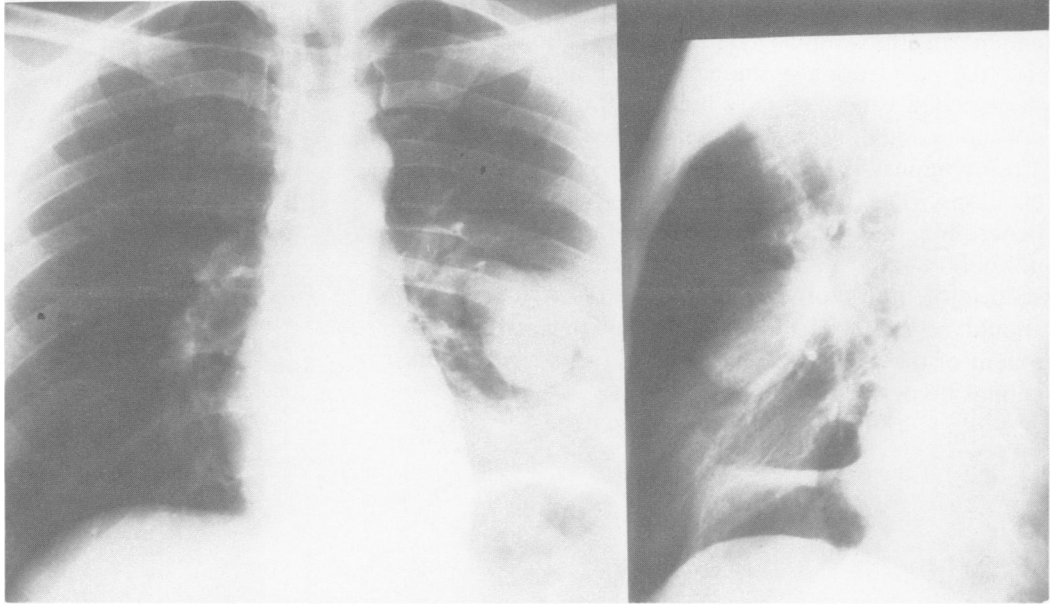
Chest roentgenogram showing two left lower lung field densities one posteriorly and another in the lingular area.
